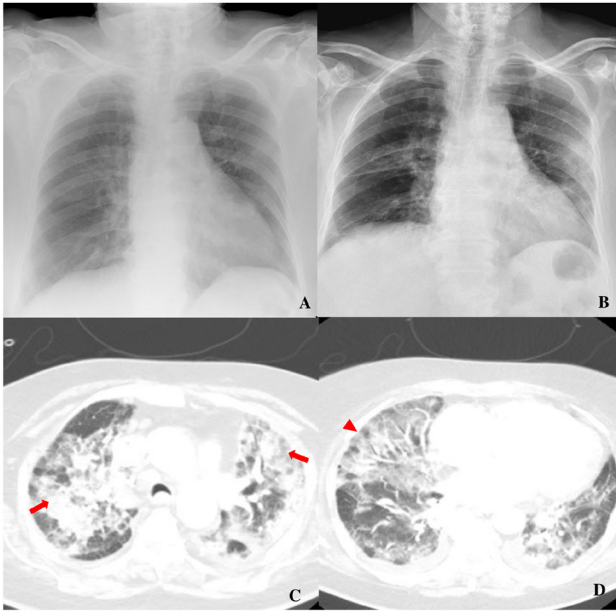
Chest X-ray showing bilateral ground-glass opacities related to SARS-CoV-2 (a) with favorable evolution (b), during the first admission.
